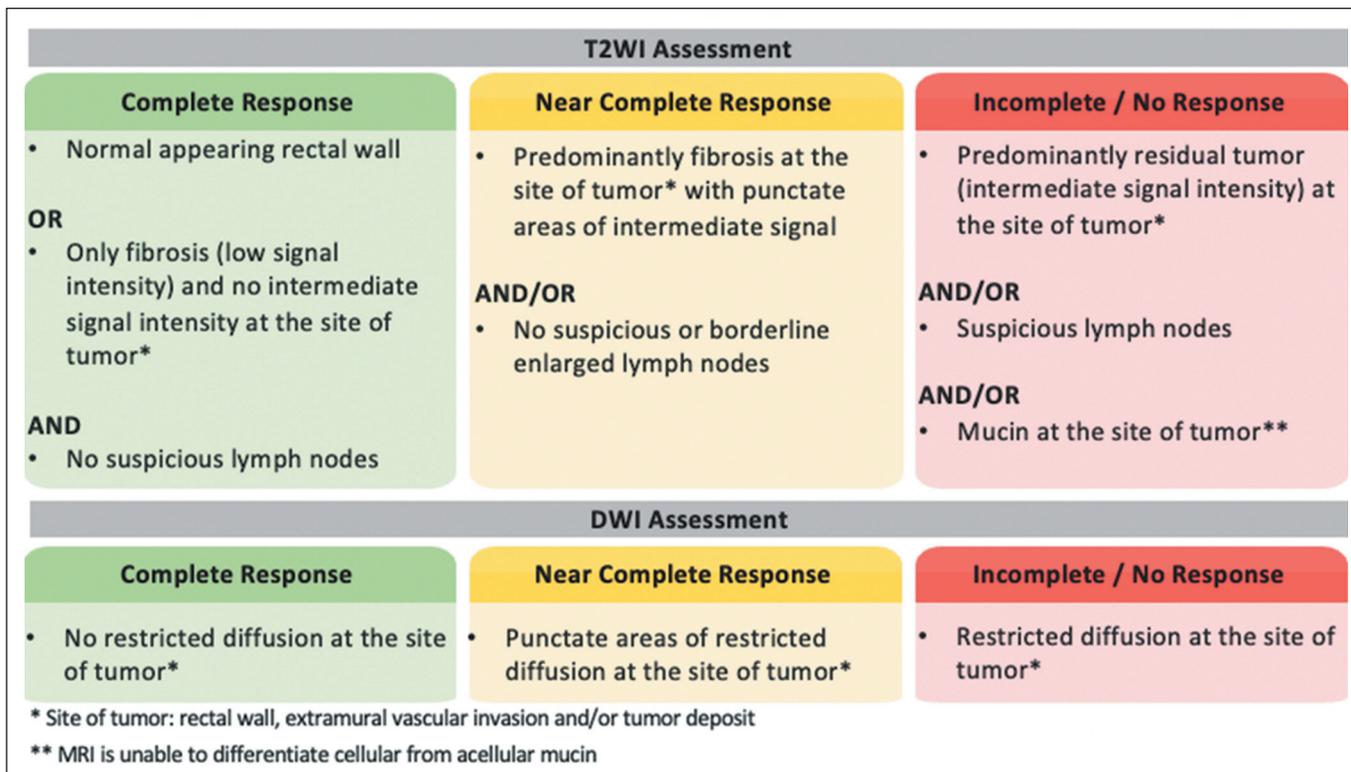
Summary of the final assessment on restaging rectal MRI.
